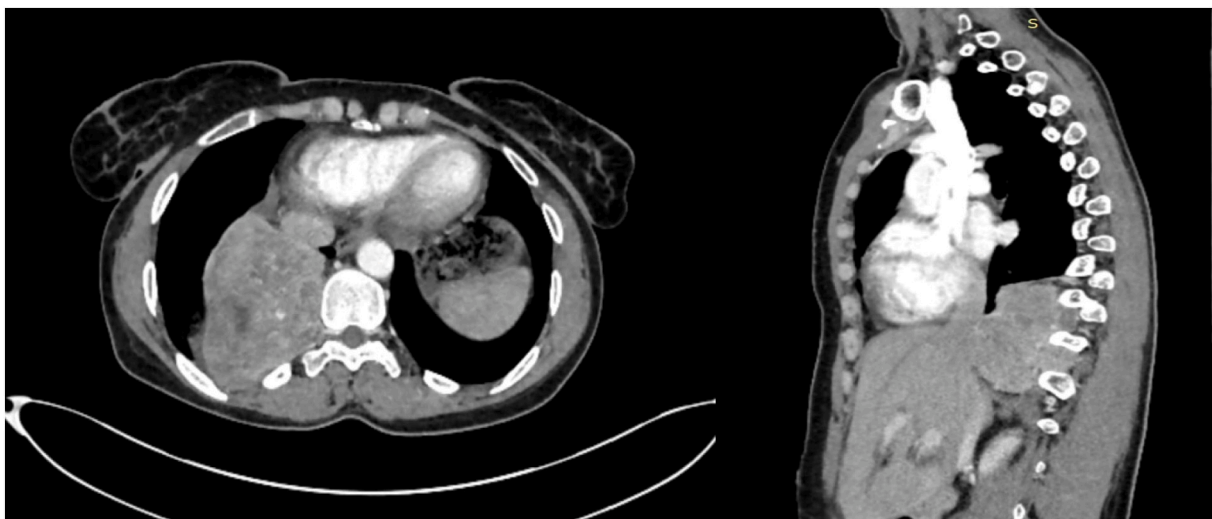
Chest CT showing a homogeneous dumbbell-shaped mass in the right posterior mediastinum with vertebral extension.
